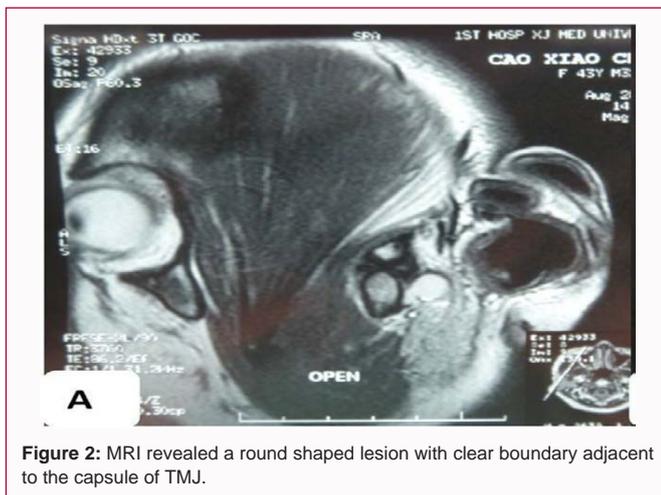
MRI revealed a round shaped lesion with clear boundary adjacent to the capsule of TMJ.
